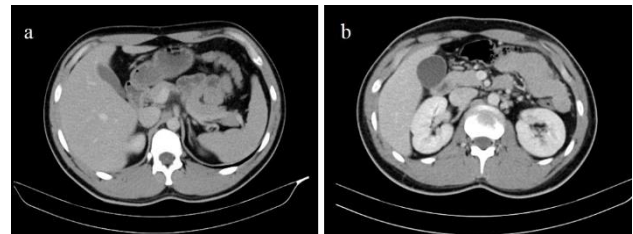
Gallbladder state on axial CT images; a. contracted, b. non-contracted
